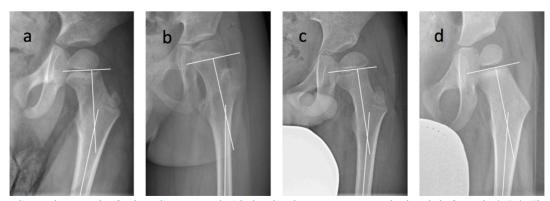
Four radiograph examples for how lines were decided to be drawn to measure the head-shaft angle (HSA). The radiographs show: (a) undulating physis: a line is drawn parallel to the epiphysis to connect the metaphysis by the lateral and medial margins; (b) round physis: a line is drawn at the base of the epiphysis, connecting the superior and inferior margins; (c) oval physis: a line is drawn through the midline of the physis; (d) rounded epiphysis: a line is drawn parallel to the proximal end of the metaphysis, since the epiphysis is rounded and does not have distinct superior and inferior margins. In all cases (a-d) a second line is drawn perpendicular to the first line and connected with a third line through the midshaft femur to form the HSA.
